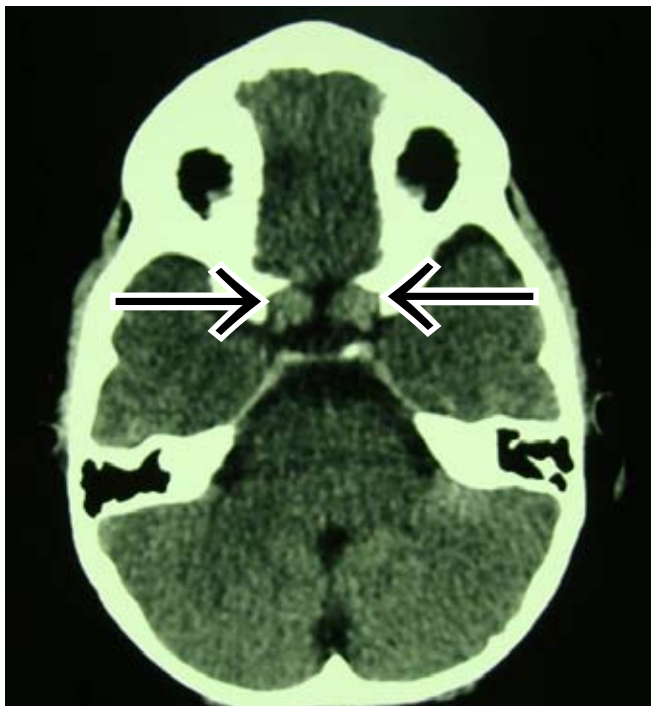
Axial non-enhanced brain CT showing bilateral gliomas at the level of the optic nerve extending into the chiasm.
